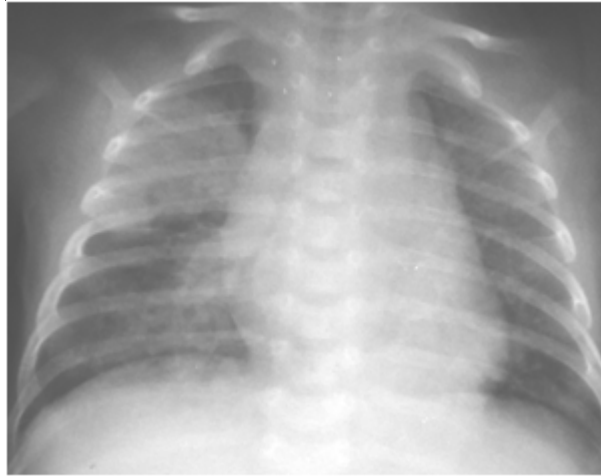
Chest X-ray showed large nodular opacities in the right upper lobe, left lower retrocardiac area, and a patchy peribronchial opacity in the right lower lobe.
